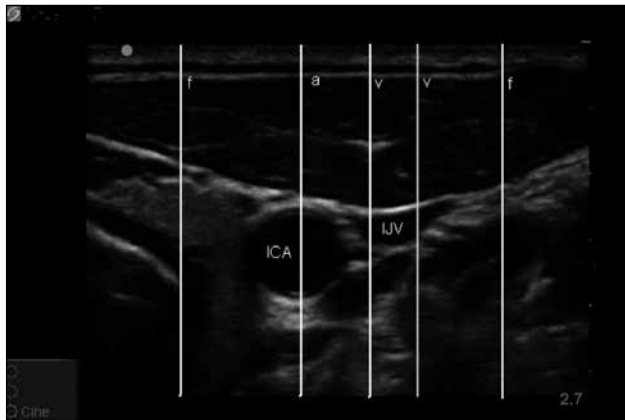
Ultrasound image showing normal right internal jugular vein anatomy in healthy volunteer. Line positions reflect: f=Fail, a=Fail, v=Pass, ICA, Internal Carotid Artery, IJV, Internal Jugular Vein
